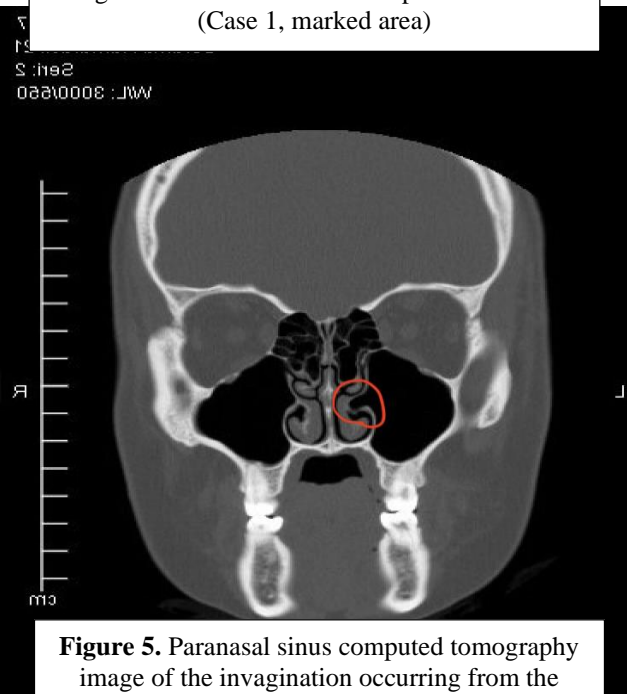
Paranasal sinus computed tomography image of the invagination occurring from the medial wall of the left maxillary sinus to the point where the left inferior turbinate is attached. (Case 1, marked area)
